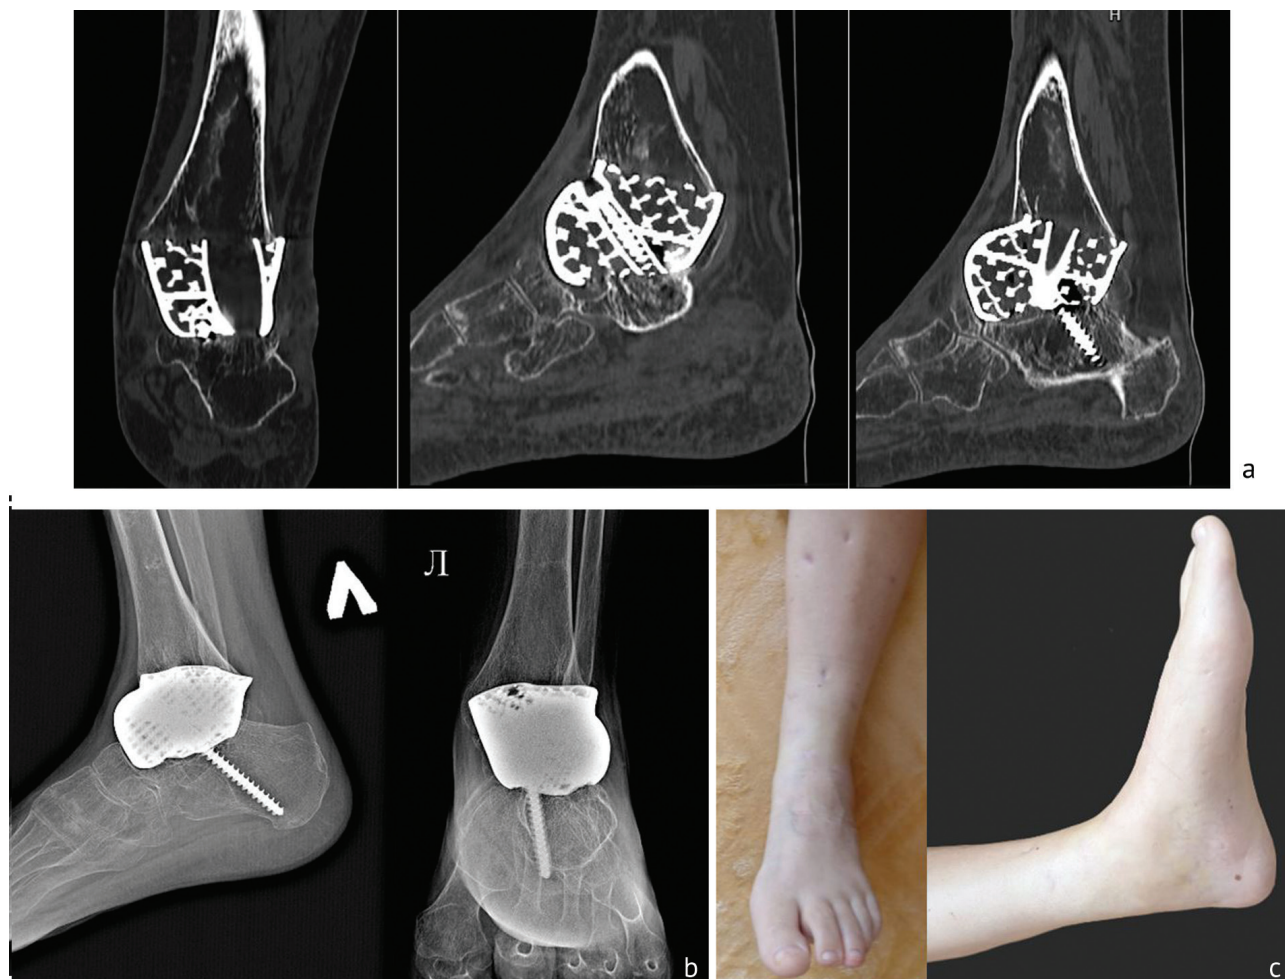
CT-scans (a); radiographs (b) and photos of the foot (c) at 10-month follow-up after Ilizarov fixator removal
